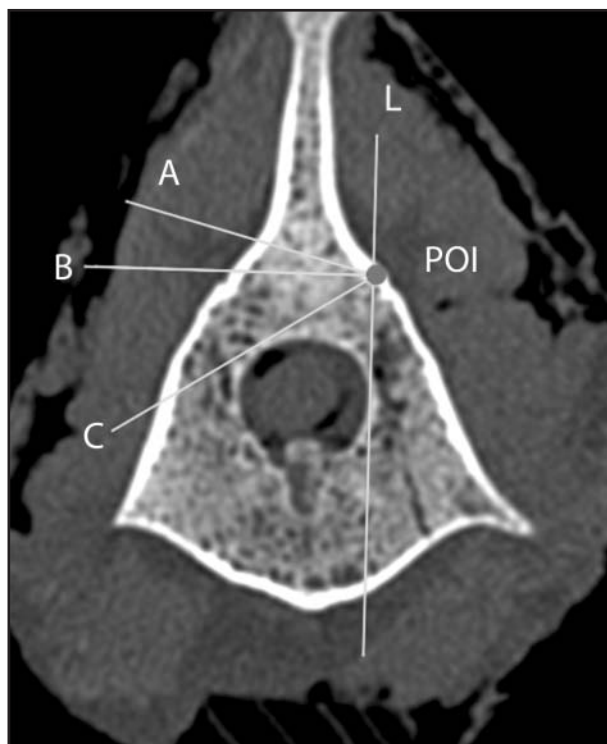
Preoperative CT image through the middle of L1 (measured in a sagittal plane from endplate to endplate) indicating the POI for the laminar screw (gray circle). This was defined as the most cranial part through a vertical line (line L) drawn at the lateral border of the vertebral canal where it intersects the outer cortex of the vertebra. Minimum and maximum angles were measured relative to a line (line B) perpendicular to line L and that bisected the POI. The minimum angle is the angle between line B and a line (line A) drawn through the POI and that includes 2 cortices of the lamina ventral to the base of the spinous process. The maximum angle is the angle between line B and a line (line C) drawn through the POI and that passes as close as possible to the vertebral canal. Minimum angle was 9.39°, and the maximum angle was 23.98°.
